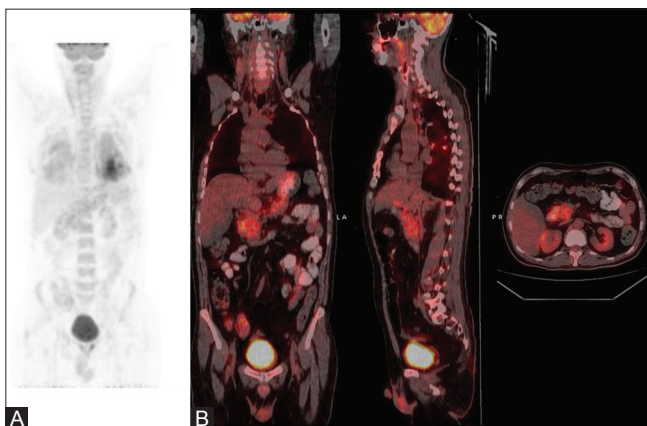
(A and B): (A) Whole body ¹⁸F-FDG PET/CT MIP and (B) fused PET/CT images: Abnormal diffuse to heterogeneous ¹⁸F-FDG uptake in the lungs, upper abdomen, bone marrow, and spleen
